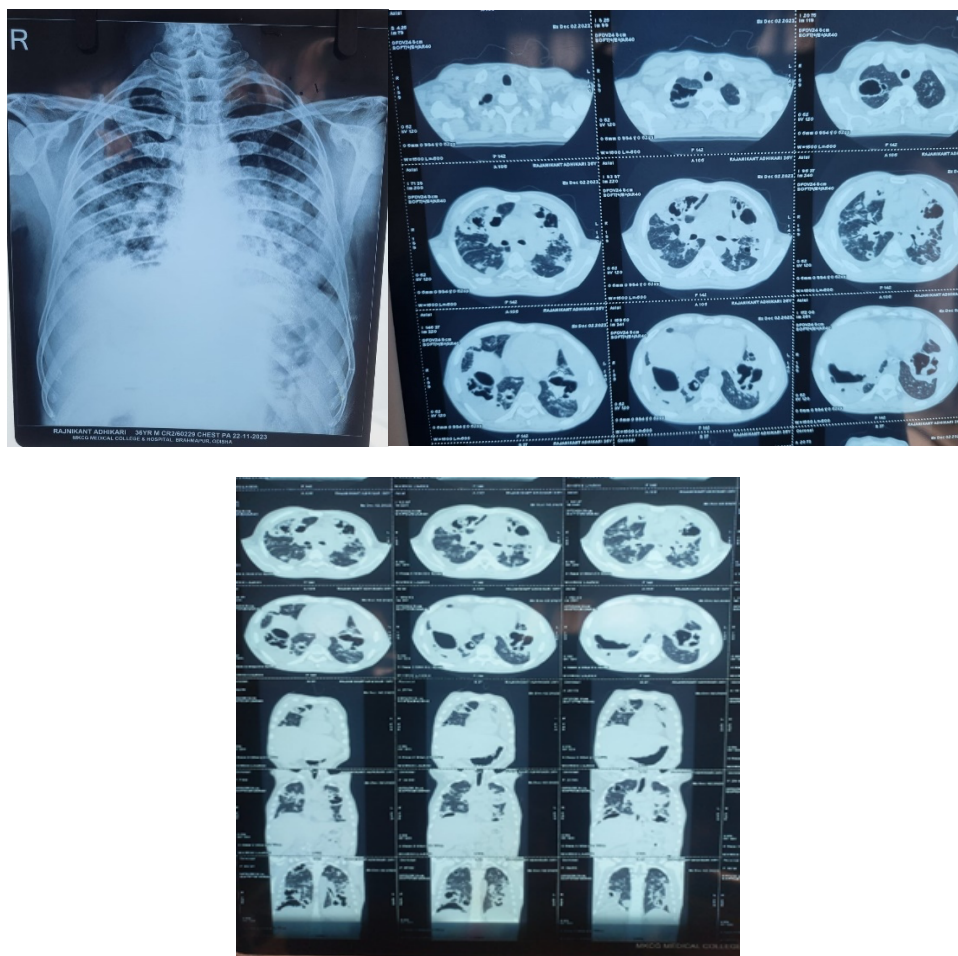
Chest X-ray and CT-scan of the patient showing bilateral moderate pleural effusion with multilobe consolidation with cavitation
